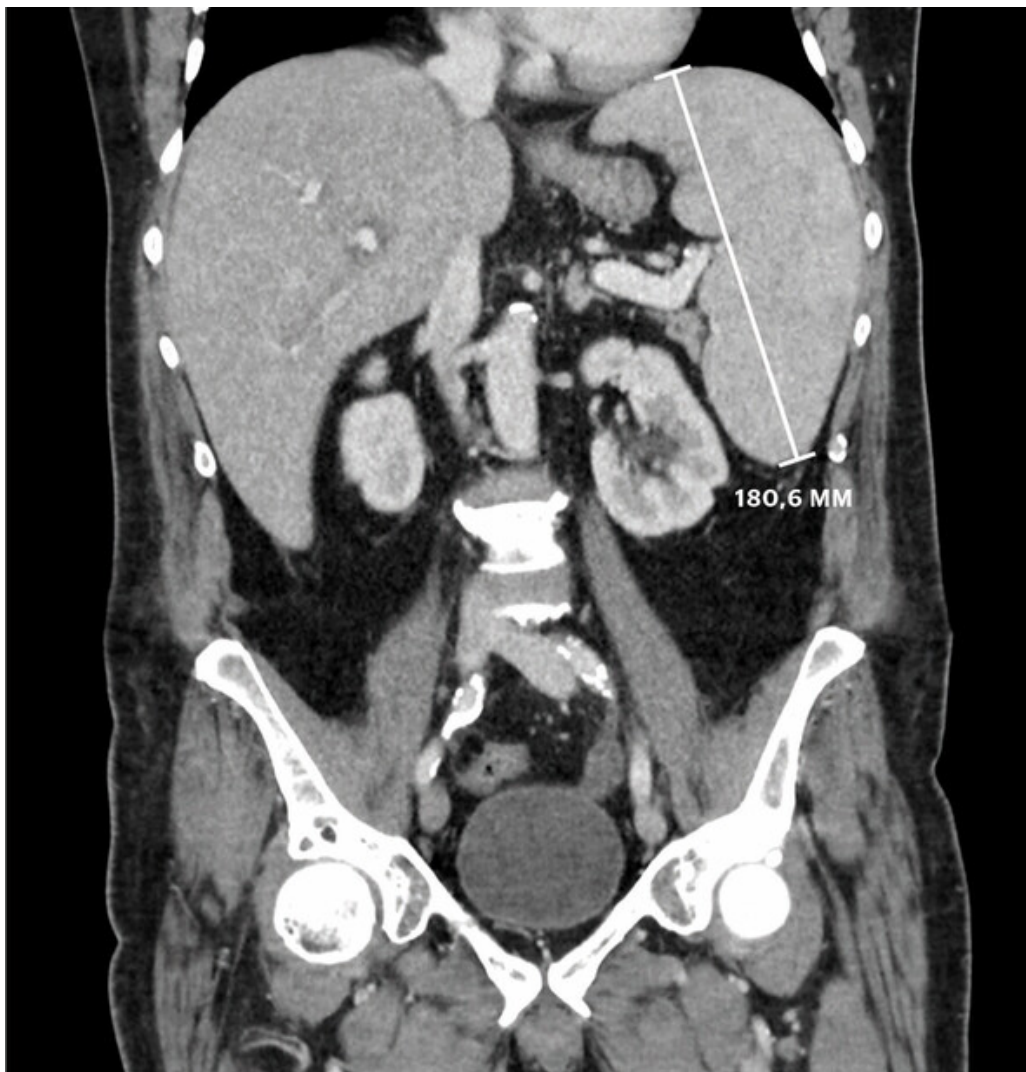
CT taken on day 13 showed an enlarged spleen (18 cm) and liver.
